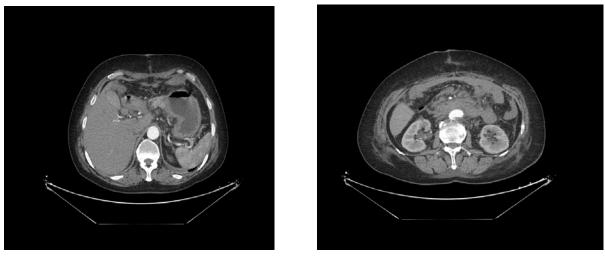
CT scan showing no evidence of free fluid in the abdomen
